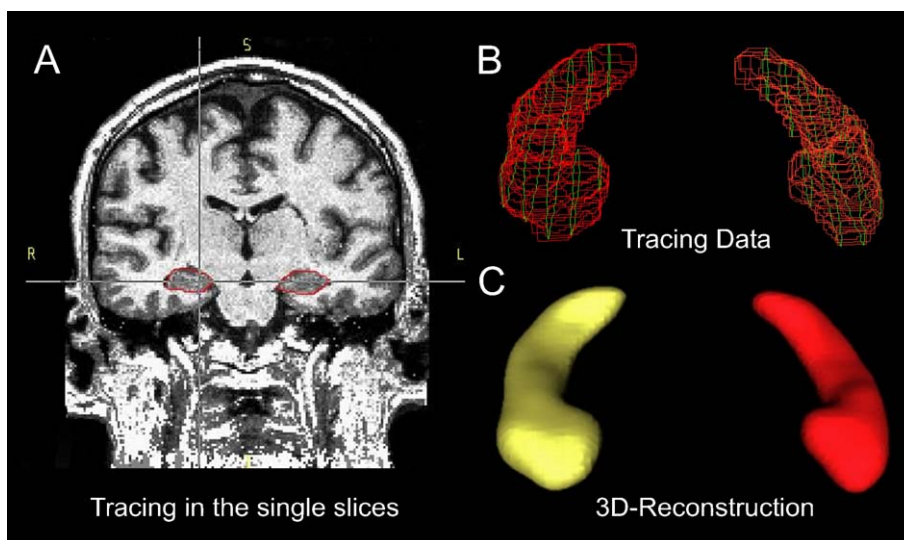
Anatomical tracing with BRAINS2 (A) MRI-data, Tracings in red of both hippocampi on an MRI image in coronal plane. (B) Borders of both hippocampi in sagittal and coronal direction. We first traced the hippocampus on every 5th slice in sagittal view for guidance, before tracing every coronal slice from the entire hippocampus. (C) 3D-reconstruction of the Hippocampus. (For interpretation of the references to colour in this figure legend, the reader is referred to the web version of this article.)
